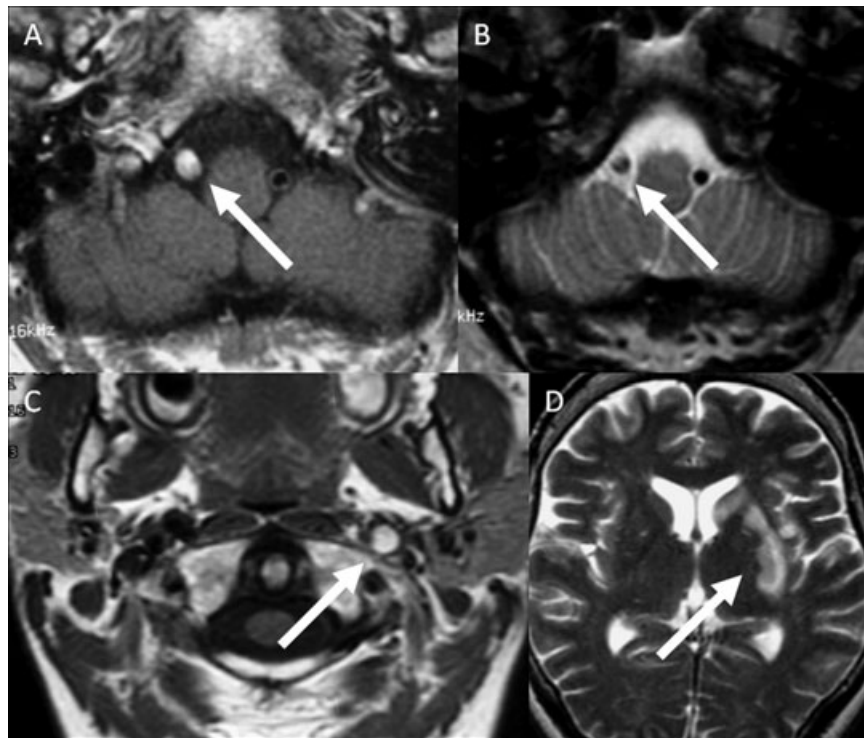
Axial T1-weighted (A, C) and T2-weighted (B, D) MR images of two children with posttraumatic vascular dissection. The first patient (A, B) suffered from a right vertebral artery dissection (arrows). The second patient (C, D) suffered from a thromboembolic left middle cerebral artery infarction because of a posttraumatic left sided internal carotid artery dissection (arrows). In both patients, the normal hypointense flow related signal void is replaced by a hyperintense thrombus within the false lumen.
